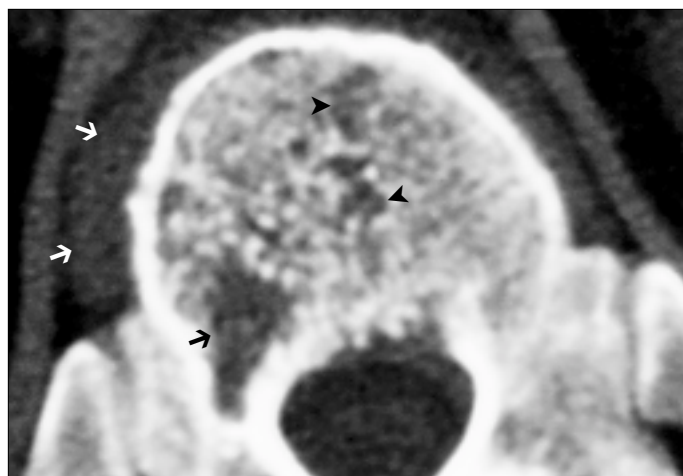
Axial CT image demonstrates an abnormal area in the right side of the T12 vertebral body (black arrow) and smaller abnormal areas (arrowheads) in the more central portion of the vertebral body. There is also an associated right paravertebral mass (white arrows).
